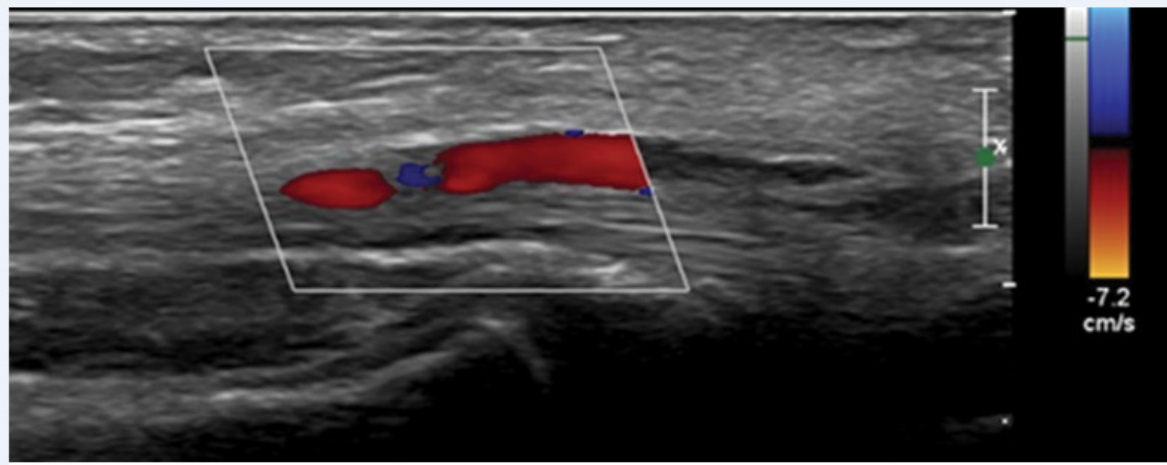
Echo-Doppler of the left upper extremity where diminished blood flow can be seen at the forearm level.
